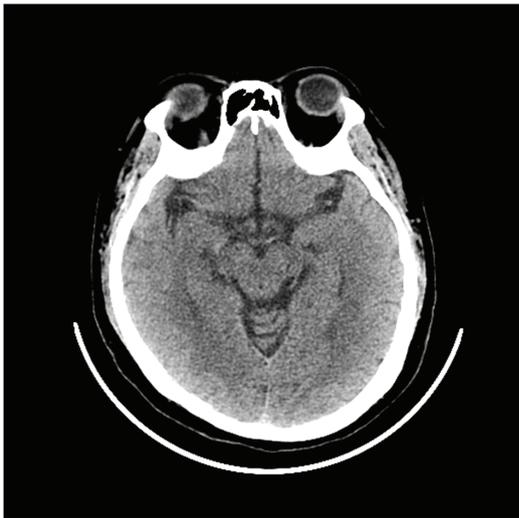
Computed tomography of the skull revealed no abnormality.
